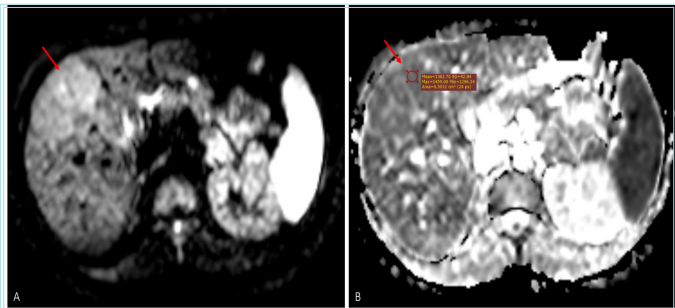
DWI (A) and ADC (B) images of a 19-year-old female patient with FNH in the liver. The lesion is localized in liver segment 8, appearing hyperintense on DWI and isointense on ADC (arrow demonstrates an example ADC measurement)
